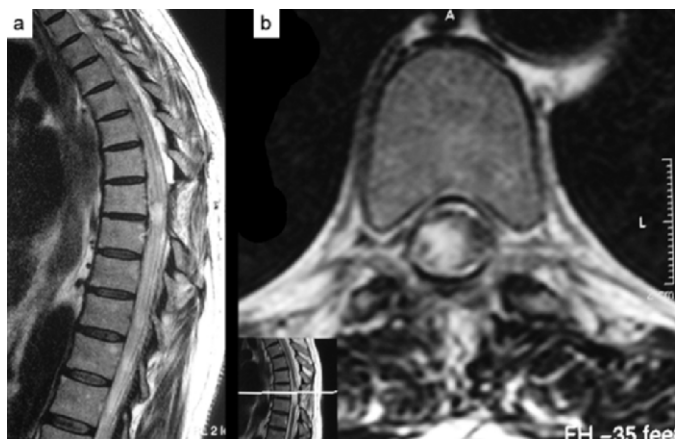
Thirty-month postoperative (a) sagittal and (b) axial dorsal MRI T2-weighted scans demonstrate reactive gliosis signal due to preoperative period squeezing of spinal cord by the dural defect.
